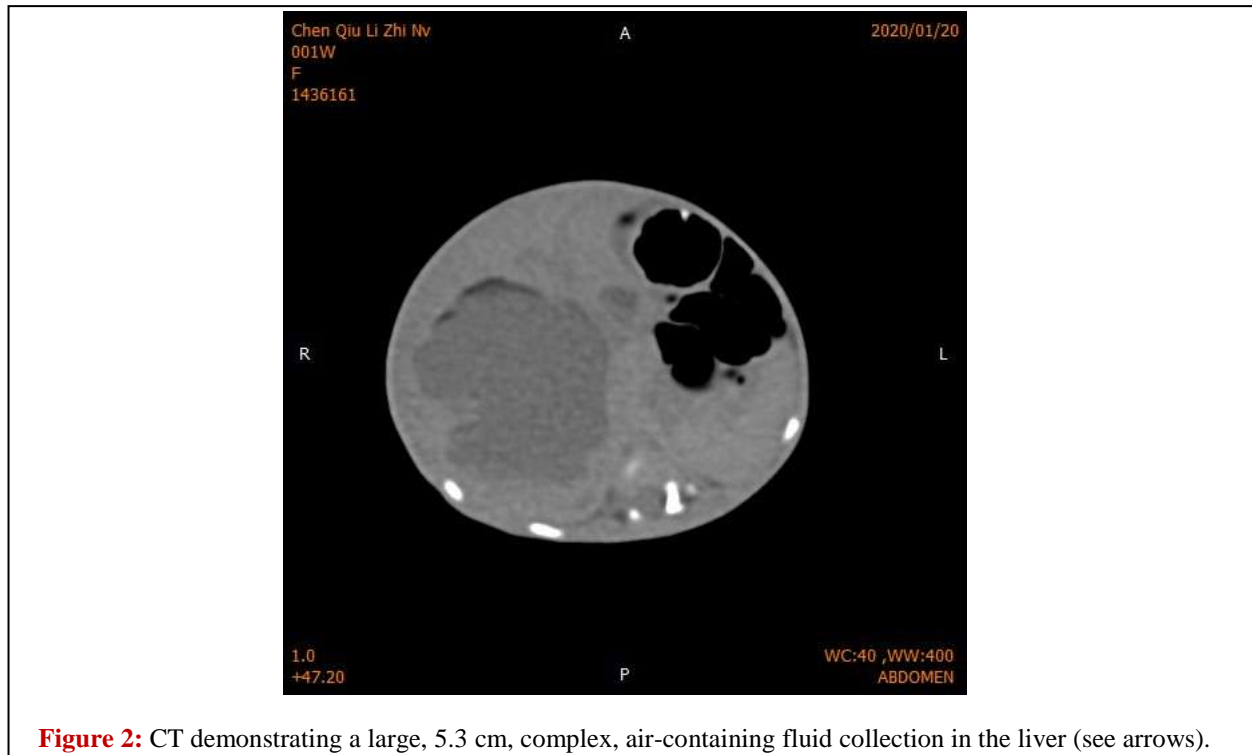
CT demonstrating a large, 5.3 cm, complex, air-containing fluid collection in the liver (see arrows).
